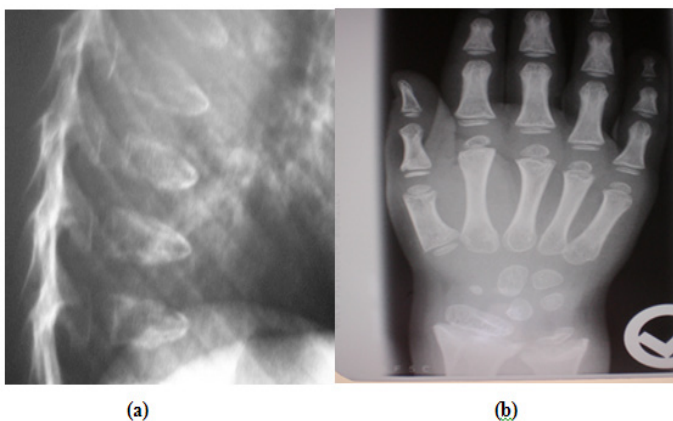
a) Lateral thoracic spine radiograph of a-six-year-old-boy with SMD (Kozlowski type) showed generalized platyspondyly (flat vertebral bodies). b) AP hand radiograph of a-12-year-old-boy with SMD (Kozlowski type) showed small carpal bones, retardation of the carpal ossification’s centres with minimal metaphyseal changes of the short tubular bones which look short and broad. Note marked metaphyseal dysplasia of the inferior ends of the radius and ulna.
